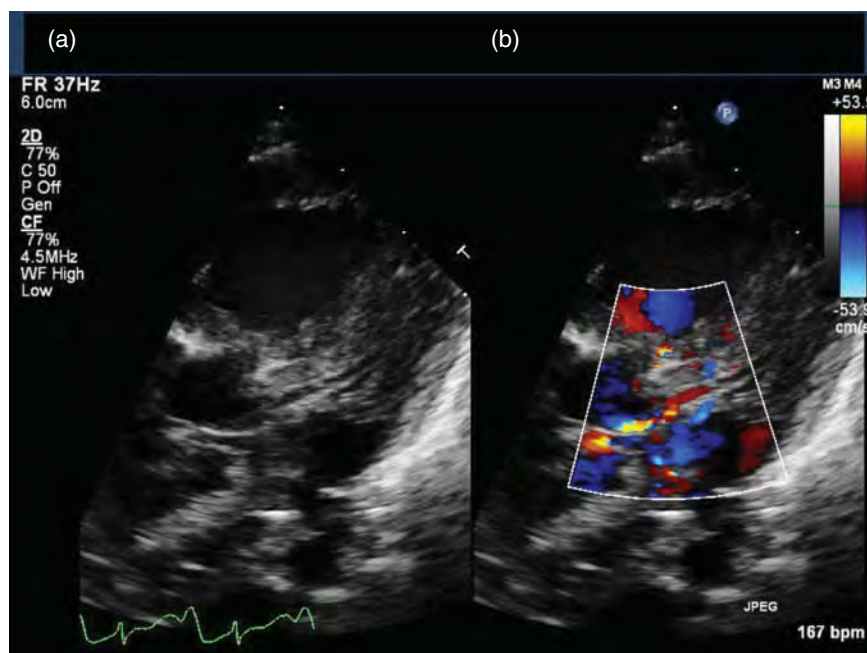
Left coronary artery stenosis. Echocardiogram in the short axis of the aortic root in: (a) 2D; and (b) with color Doppler. The left coronary artery ostium is located in the posterior aspect of the left sinus of Valsalva. Color Doppler shows turbulent flow across the LCA ostium, suggestive of ostial stenosis.
